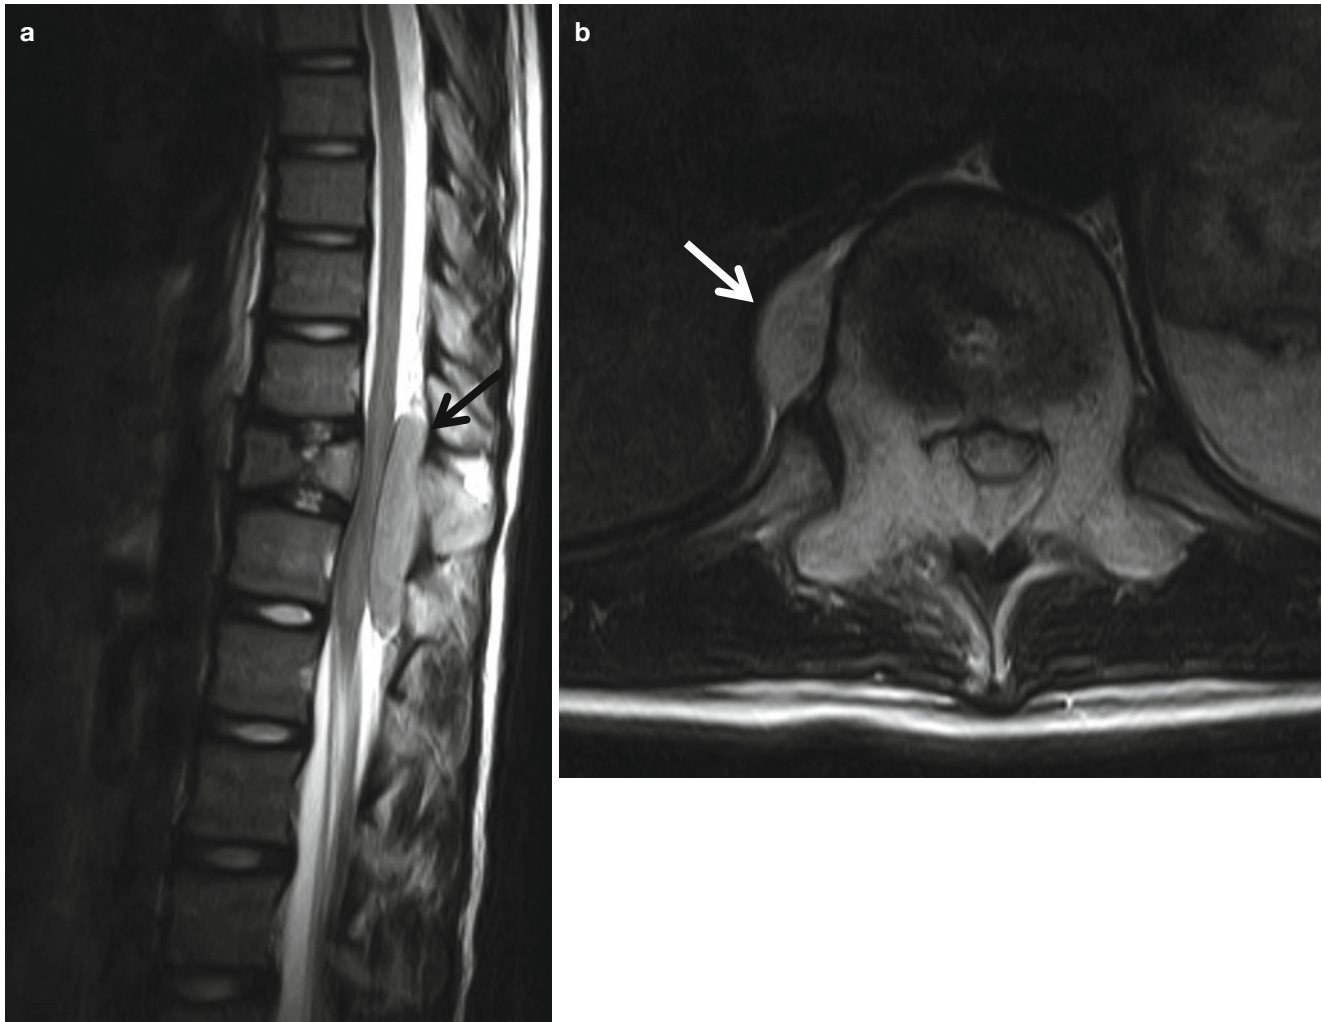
PNET involving the spine forming epidural mass. (a) T2-weighted sagittal image demonstrates isointensity mass (*arrow*) posterior to the thoracic cord. T11 body is compressed, and posterior element is also involved. (b) Axial image at the level of T11 shows
